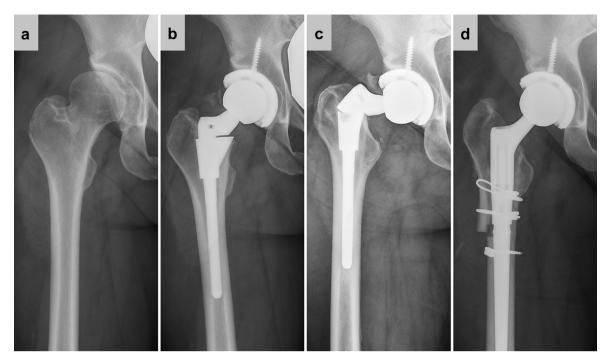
Chronologic radiographs (a) October 2, 2013 preoperative anteroposterior radiograph of the right hip showing secondary osteoarthritis due to hip dysplasia (b) December 18, 2014 postoperative radiograph of the right hip after total hip arthroplasty with a S-ROM prosthesis and a Pinnacle cup (c) July 5, 2017 follow-up radiograph of the right hip showing a fracture of the femoral component at the level of the sleeve-stem junction with a valgus malalignment (d) August 14, 2017 postoperative radiograph of the right hip after revision performing and ETO, implanting of a Restoration Modular Hip System and reposition of the greater trochanter with Dall-Miles cables. The original cup could be preserved.
